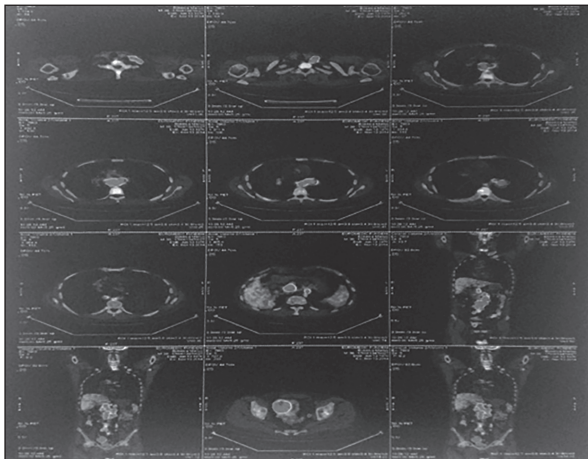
Thoracic CT scan. Left endobronchial tumor and enlarged mediastinal lymph nodes.
